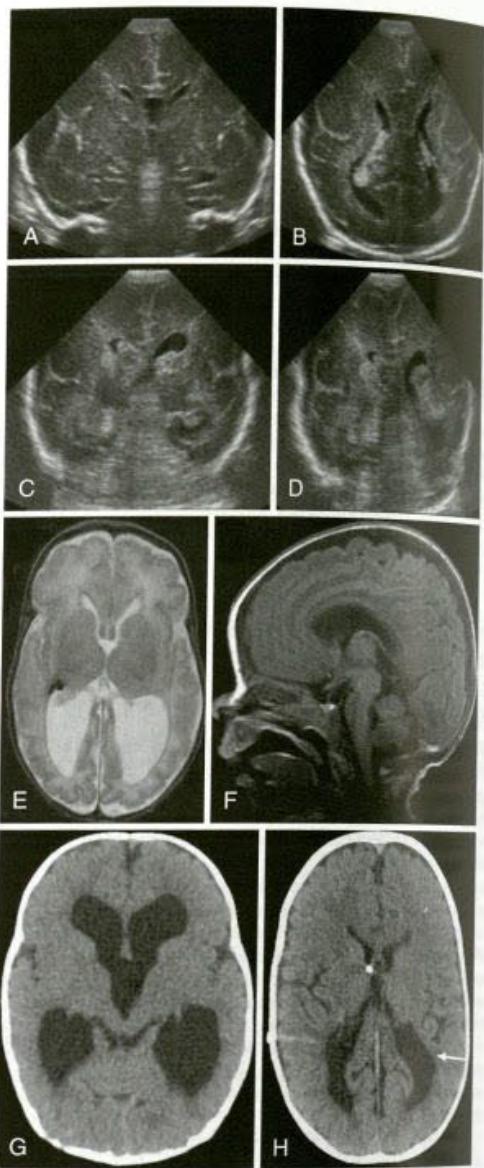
Typical imaging findings in posthemorrhagic hydrocephalus from germinal matrix hemorrhage after preterm birth at 27 weeks' gestation. Cranial ultrasonography (US) in the coronal (A) and axial (B) planes at 12 hours of life shows minimal abnormalities. Repeat US 2 days later reveals bilateral grade IV intraventricular hemorrhage (C and D), also termed periventricular hemorrhagic infarction. The patient did not develop signs of symptomatic hydrocephalus as a neonate. At term equivalent, magnetic resonance imaging shows a paucity of white matter, suggesting the diffuse form of periventricular leukomalacia (E). Also note the small cerebellum, a typical finding among former preterm infants (F). At 8 months of age he developed symptomatic hydrocephalus, with an enlarging head circumference and dilated ventricles observed on CT (G). Several months later, a baseline CT scan shows well-decompressed ventricles, but the paucity of white matter remains (H, arrow).
